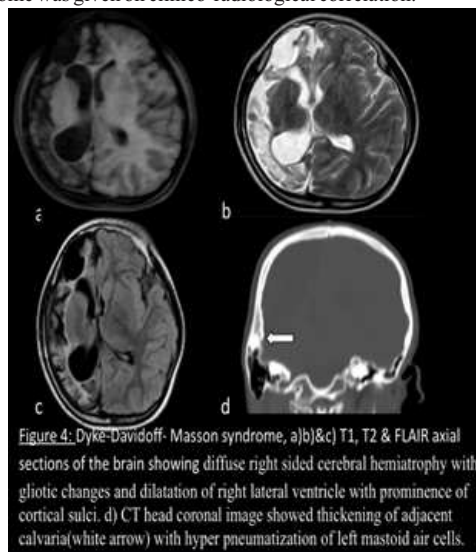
Dyke-Davidoff-Masson syndrome. a) b) & c) T1, T2 & FLAIR axial sections of the brain showing diffuse right sided cerebral hemiatrophy with gliotic changes and dilatation of right lateral ventricle with prominence of cortical sulci. d) CT head coronal image showed thickening of adjacent calvaria (white arrow) with hyperpneumatization of left mastoid air cells.
